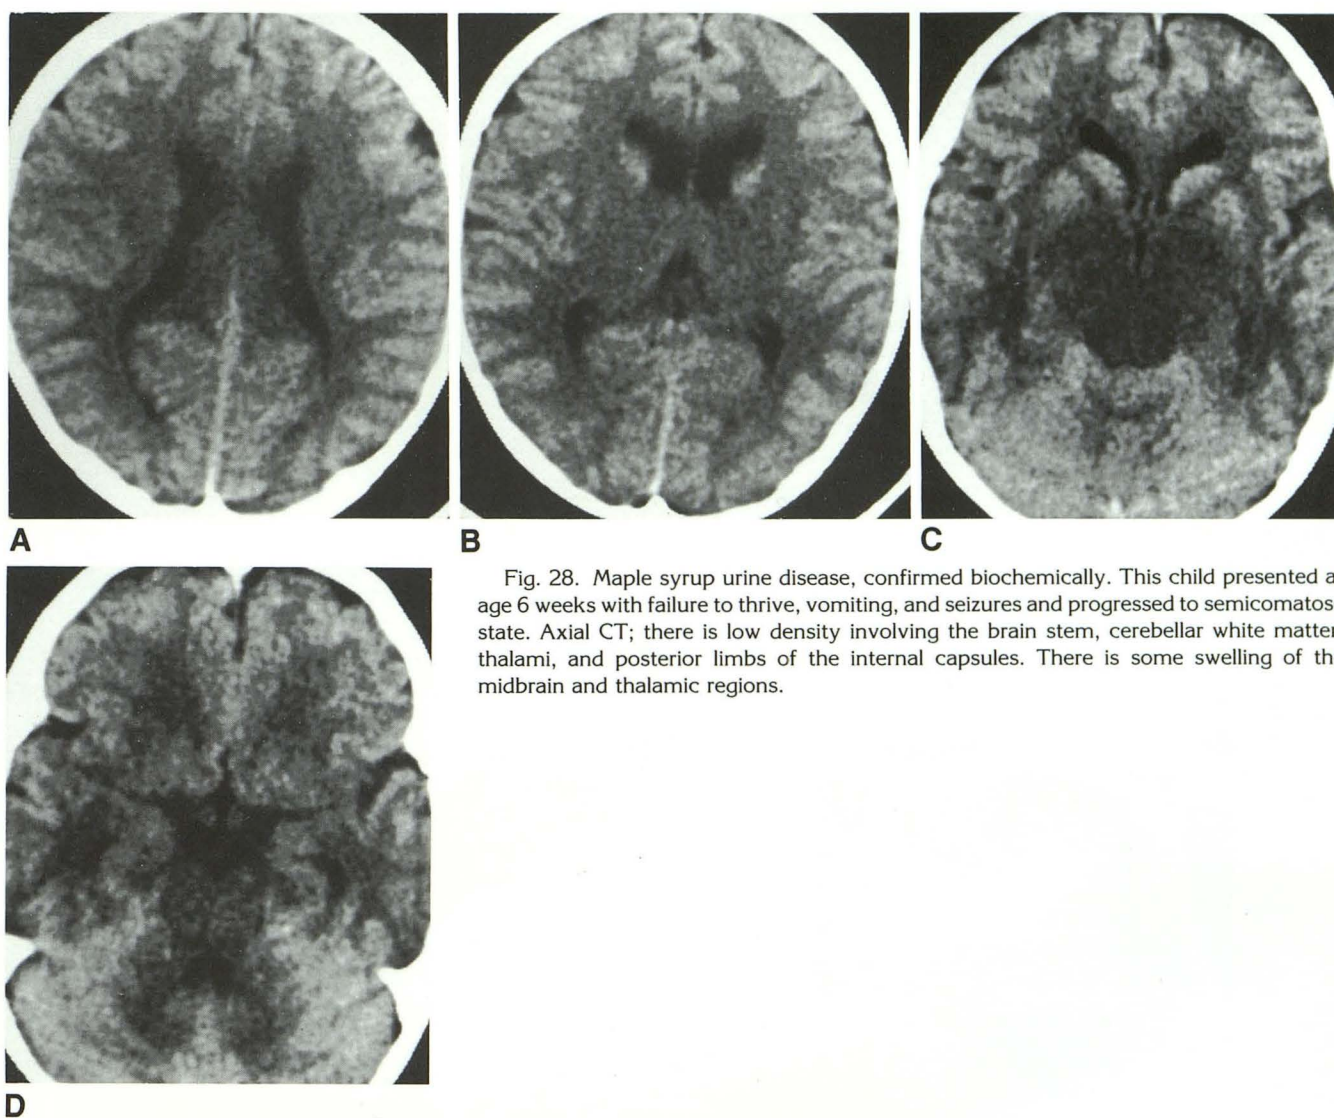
Maple syrup urine disease, confirmed biochemically. This child presented at age 6 weeks with failure to thrive, vomiting, and seizures and progressed to semicomatose state. Axial CT; there is low density involving the brain stem, cerebellar white matter, thalami, and posterior limbs of the internal capsules. There is some swelling of the midbrain and thalamic regions.
